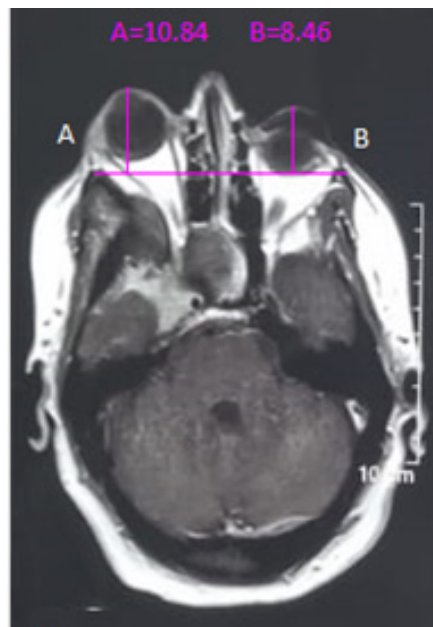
Patient with right SOM and Radiological measurement of exophthalmos index (EI) on preoperative T1-weighted axial MR image with contrast. A slice passing through the lens on both sides was chosen. The distance in millimeters was calculated from the most anterior aspect of each globe on a section (including the lens) to a line between the anterior tips of the frontal processes of the zygomas. The EI was measured as the ratio of the distance on the pathological eye (the ipsilateral side of the tumor) to the same distance on the normal eye (the contralateral side of the tumor) (EI=A/B = 10.84/8.46 = 1.28 in this case).
